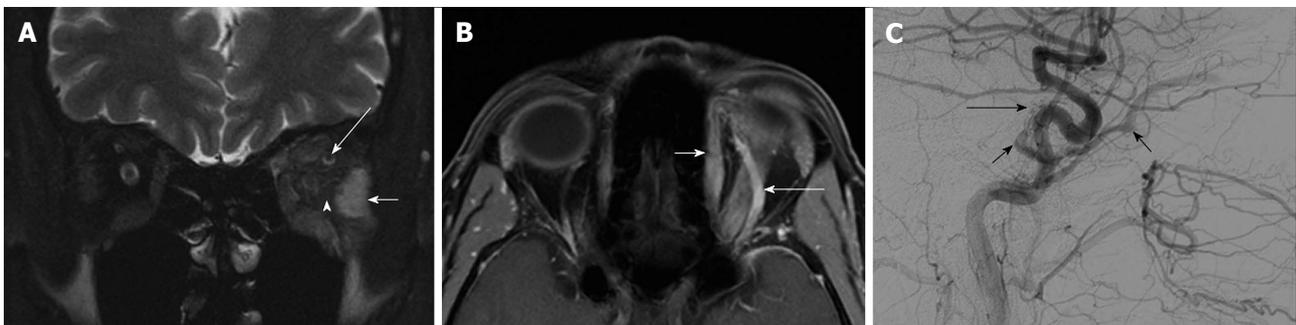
Indirect carotid-cavernous fistula. A: Coronal T2 MRI with fat saturation demonstrating mild infiltration of orbital fat (arrowhead) and thickening with high signal intensity in the EOMs. In this image, the lateral rectus muscle appears brightest (short white arrow). Note the enlarged SOV (long white arrow), suggesting CCF over myositis; B: Axial post-gadolinium T1 MRI with fat saturation. The SOV (long white arrow) is engorged secondary to retrograde flow from the cavernous sinus. The superior oblique muscle (short white arrow) is also enlarged; C: Angiogram with lateral projection common carotid artery injection (patient facing to the right) showing abnormal early filling in the cavernous sinus and SOV (short black arrows), as well as an abnormal tangle of vessels along dorsal surface of cavernous sinus (long black arrow), representing abnormally dilated intracavernous ICA branches. MRI: Magnetic resonance imaging; EOM: Extraocular muscles; SOV: Superior ophthalmic vein; CCF: Carotid cavernous fistula; ICA: Internal carotid artery.
